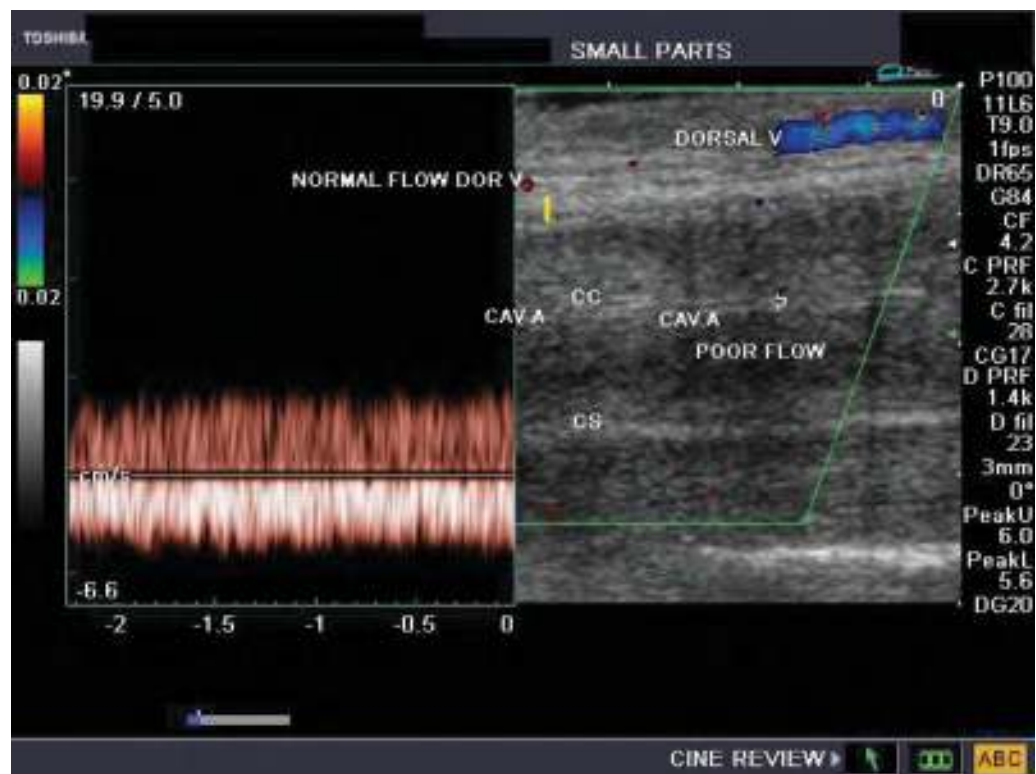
Transverse color spectral Doppler ultrasound image of the penile shaft in ischemic priapism. CAV A, cavernous artery; CC, corpus cavernosum; CS, corpus spongiosum; v, vein. (Image courtesy of Joe Anthony, MD, from his website: www.ultrasound-images.com.)
